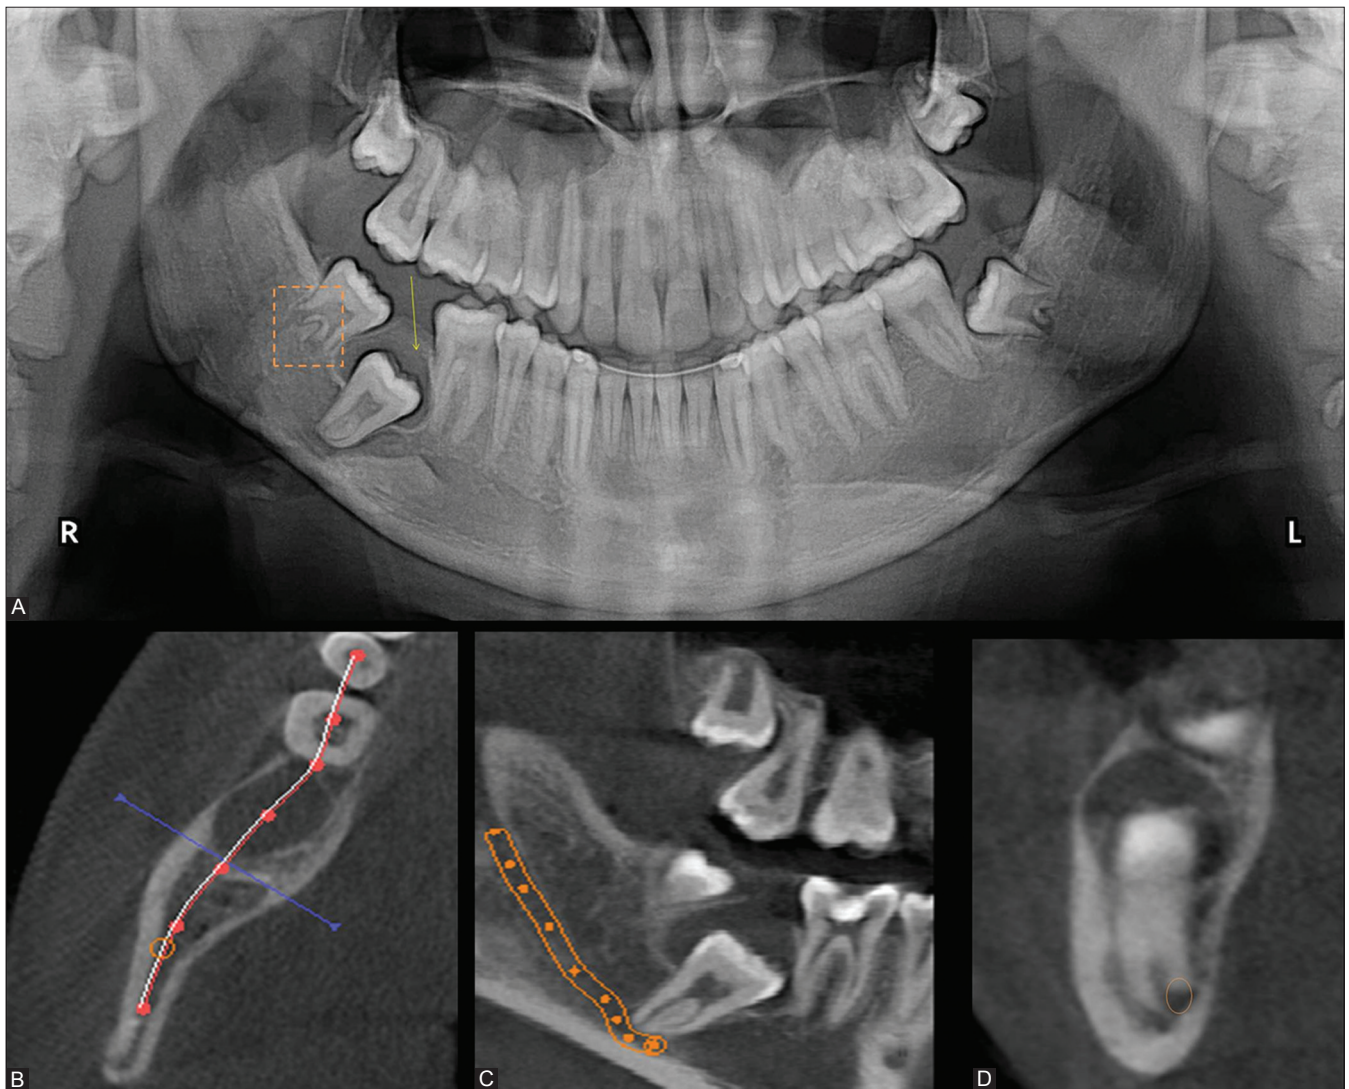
(A-D): Radiographic examination in case 1: (A) Orthopantomograph reveals the crown of impacted thirty one surrounded by a radiolucent lesion (arrow), incomplete root formation in thirty two (square), (B-D) CBCT images reveal the course of the inferior alveolar nerve and the intimate association of the roots of thirty one with the nerve
